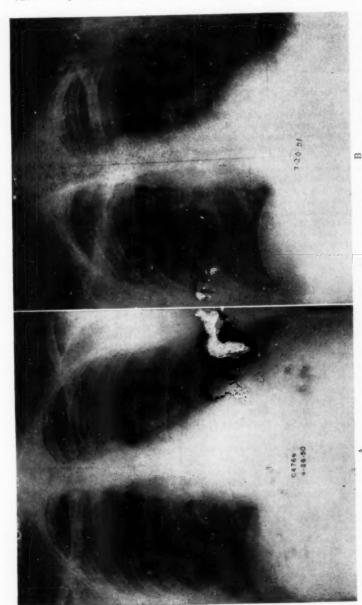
Roentgenogram of the chest taken April 26, 1950: maximal transverse diameter of the cardiac shadow 15.7 cm., 15 to 20 per cent above the expected normal. B. Roentgenogram of the chest taken July 20, 1951: maximal transverse diameter of the cardiac shadow 13.9 cm., normal.
